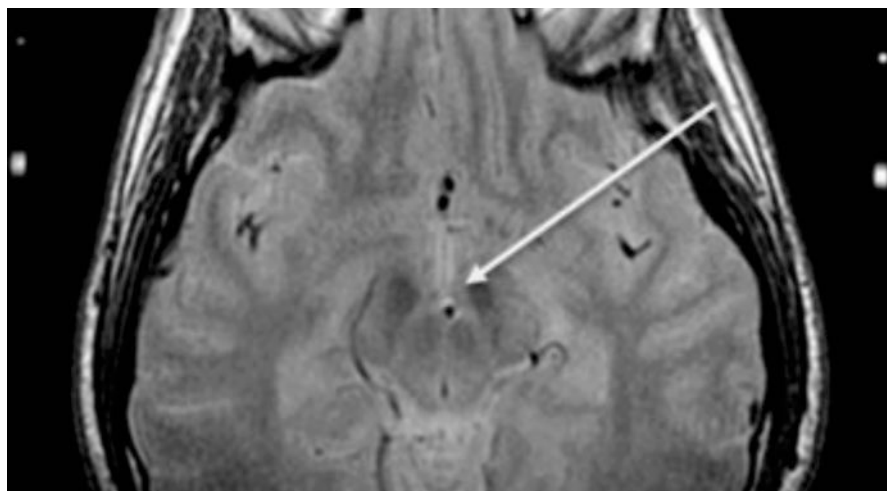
An axial T2-weighted 1.5T MRI through the midbrain following right ventral tegmental area DBS. The lead artefact can be seen in between the hypointense red nucleus and mammillothalamic tract
